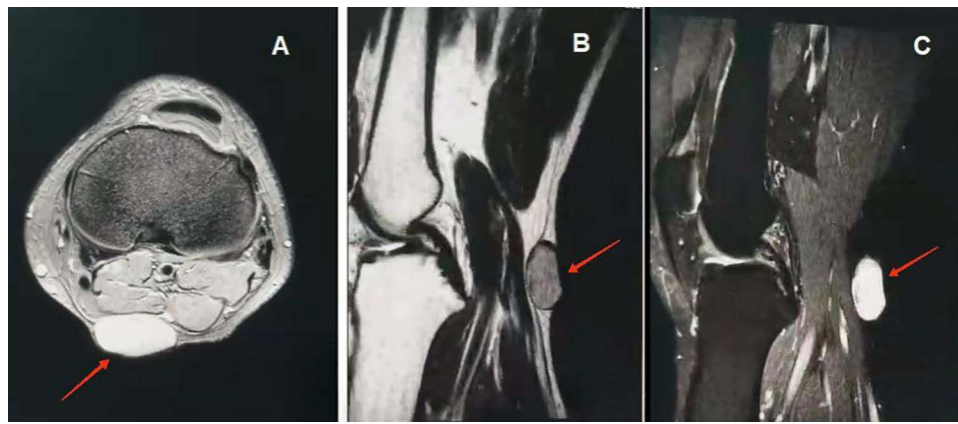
MRI images of the left knee. (A) Axial imaging demonstrates a T2 hyperintense lesion (red-arrow), centered within the subcutaneous fat. The lesion abuts both the skin and the underlying muscles without evidence of invasion. (B) The well-defined cystic lesion (red-arrow) appears isointense, suggesting proteinaceous content (T1 sagittal view). (C) The hyperintense lesion (red-arrow) in the T2 Fat-Saturated sequence.
